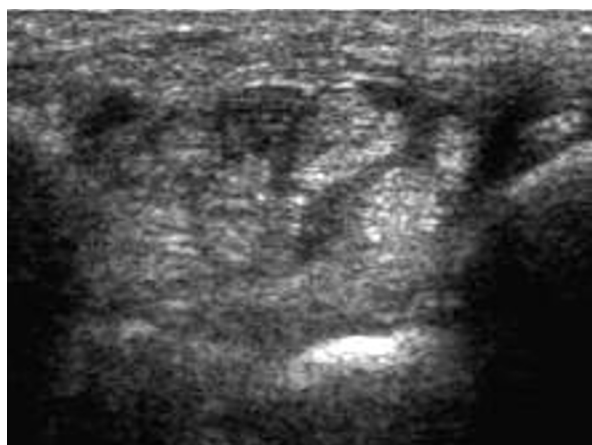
Carpal tunnel syndrome in a 56-year-old woman. Transverse sonographic scan shows triangular deformation of the slightly enlarged (11 mm²) median nerve cross-section
